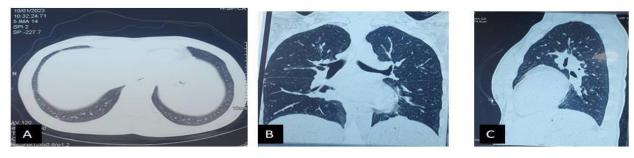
CT scan of the thorax 2 years later showing (A: axial, B: frontal, C: coronal) no
